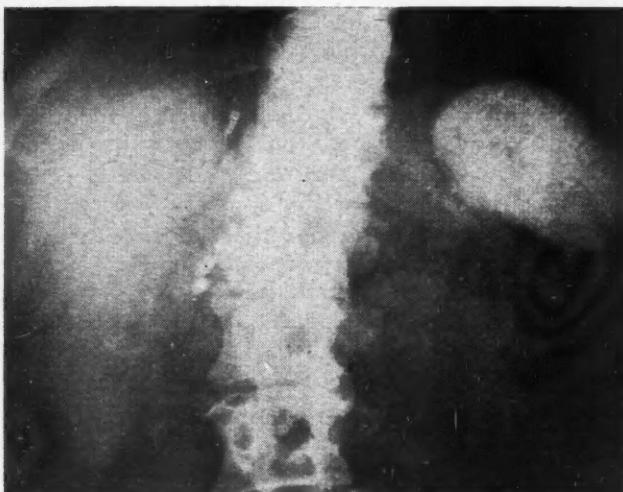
Radiograph of the upper abdomen 19 years after intracarotid injection of 20 c.c. of thorotrust. Note the fairly homogeneous, dense liver shadow, the spotty dense spleen shadow, and the dense lymph nodes of the porta hepatis.
